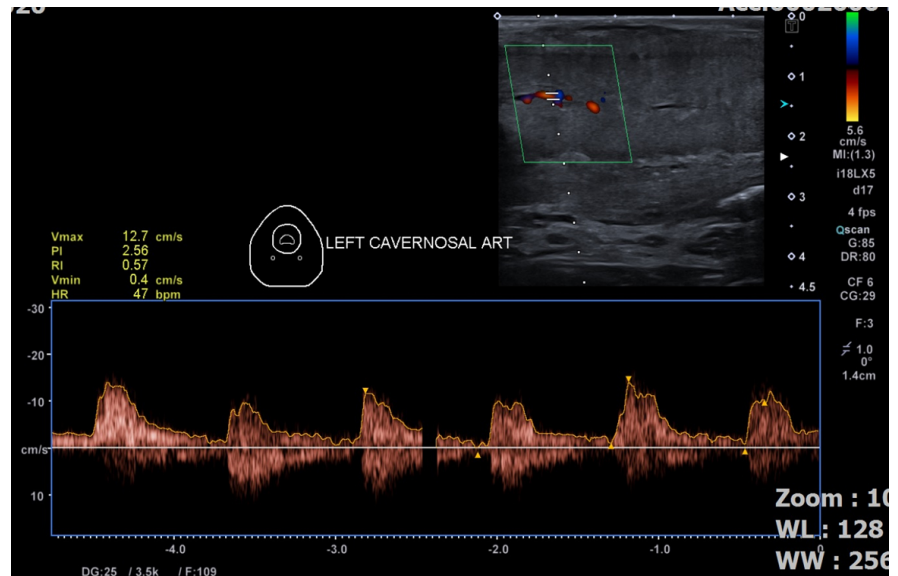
Doppler Ultrasound multiple ill-defined masses in corpus cavernosum bilaterally and subcutaneous tissues.
